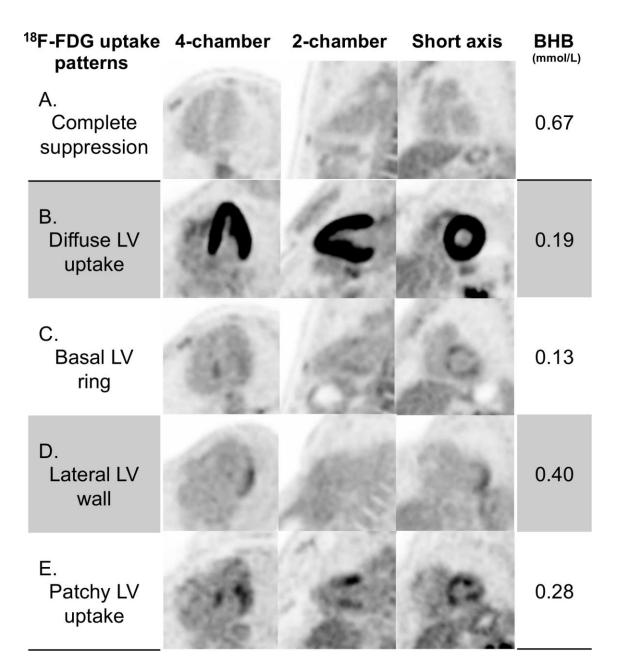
Myocardial FDG Uptake Patterns in Healthy Volunteers
